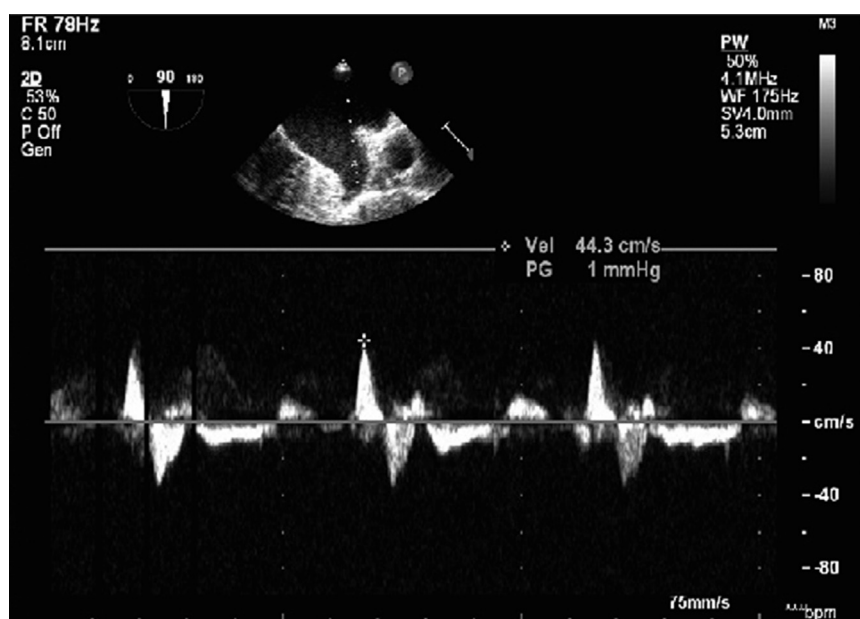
Transesophageal echocardiogram depicting pulsed-wave Doppler signal of the left atrial appendage. Peak left atrial appendage ejection velocity (44.3 cm/sec) in this representative patient is demonstrated in the lower half of the figure.
